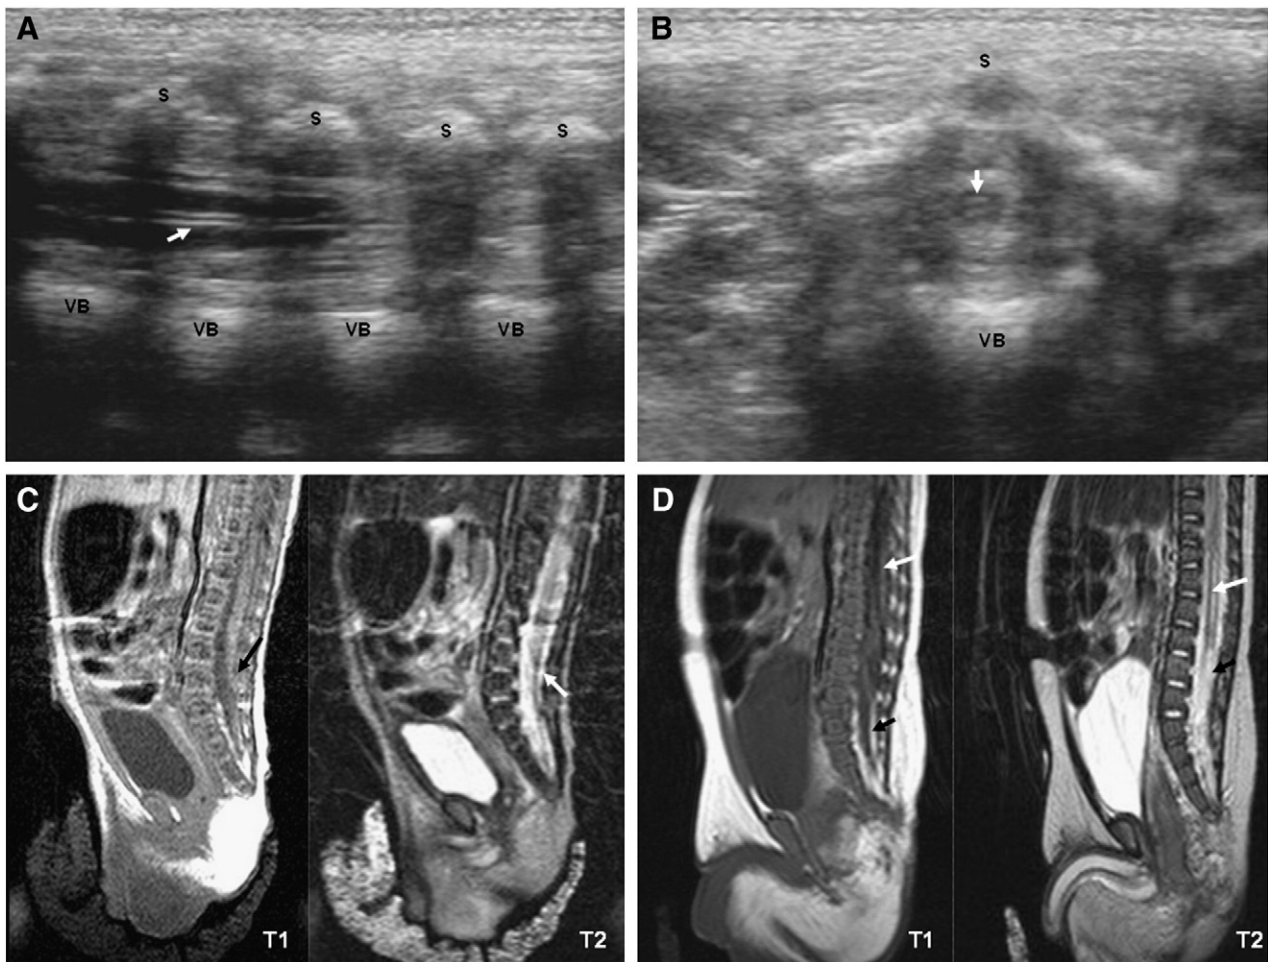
Representative US and MRI findings of the lumbosacrum in occult spinal dysraphism in a patient with an ARM (rectobulbourethral fistula). (A and B) Longitudinal section (A) and transverse section (B) from spinal US on postnatal day 4 showed no remarkable finding in the lower vertebral bodies (VB) and spinal cord. Transient dilation of the central canal, a normal variant in a newborn, was noted (white arrows). Dorsal acoustic shadows caused by the echogenic spinous processes (S) were noted. (C) Lumbosacral MRI on postnatal day 5 showed low-lying conus medullaris (L4-L5) (white arrow) with thickened filum terminale combined with fibrolipoma (black arrow). (D) Follow-up MRI on postnatal day 95 showed a large syrinx (white arrows), producing low signal intensity in the dilated spinal cord on the sagittal T1-weighted image. The thickened filum terminale was still noted at a low lumbar level intertwined with the fibrolipoma (black arrows). There was no evidence of sacrococcygeal dysplasia. The patient underwent total laminectomy (L4, L5) and removal of intradural lipoma for detethering of the spinal cord. T1 indicates T1-weighted image; T2, T2-weighted image.
